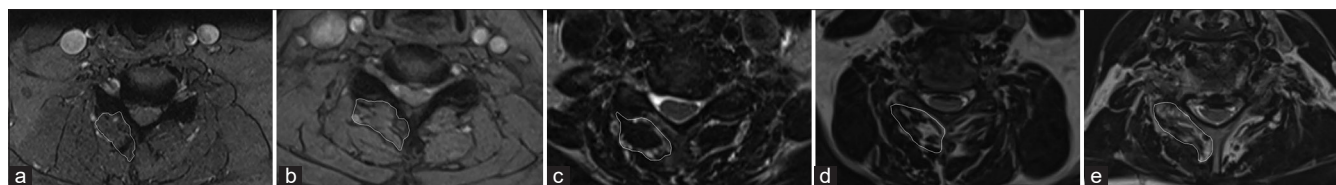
Axial T2-weighted magnetic resonance imaging at C5/C6 demonstrates Goutallier Grades 0–4 in the multifidus muscle (outlined in white): (a) No fat. (b) Minimal fat. (c) Muscle greater than fat. (d) Muscle equivalent to fat. (e) Fat greater than muscle
